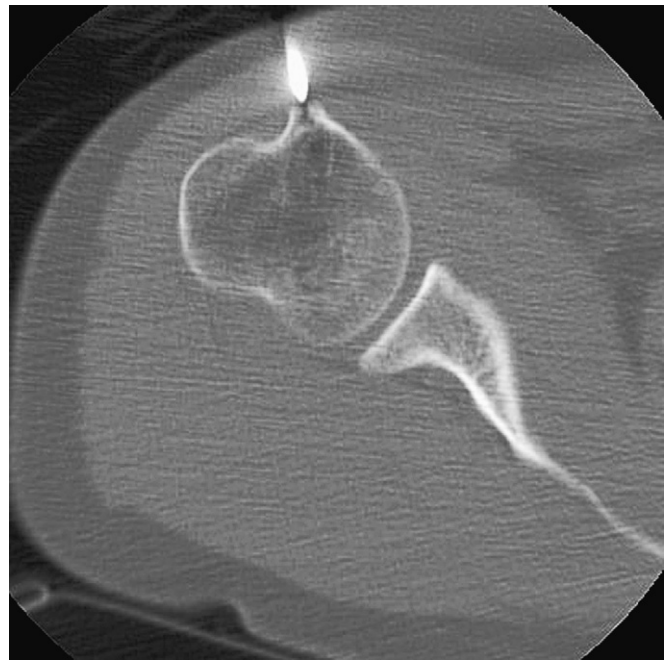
Axial computed tomography cut showing the biopsy needle in place.
